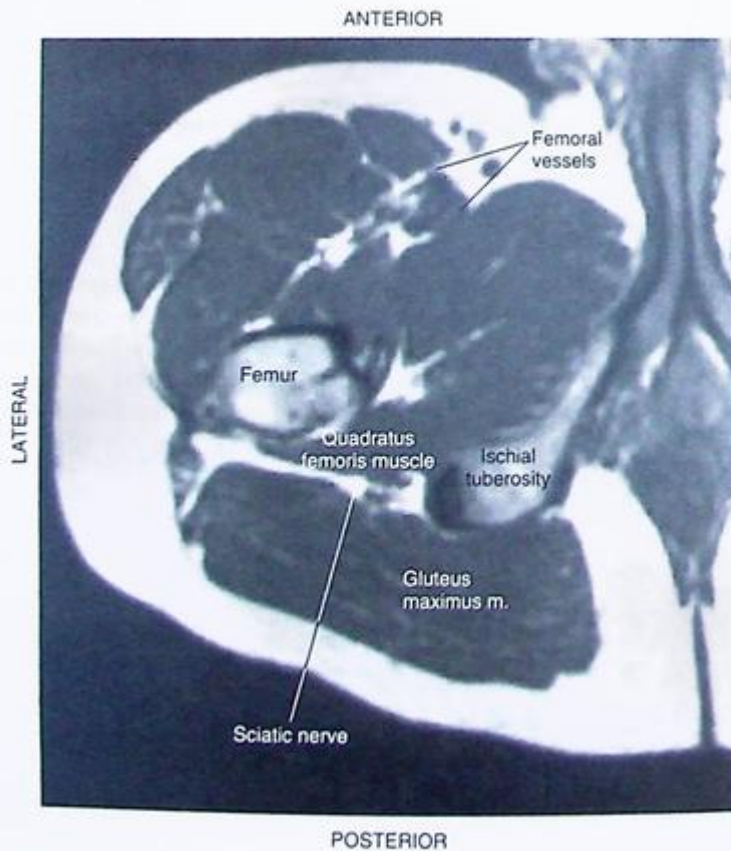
Magnetic resonance image (cross-sectional) at level of anterior sciatic nerve.
